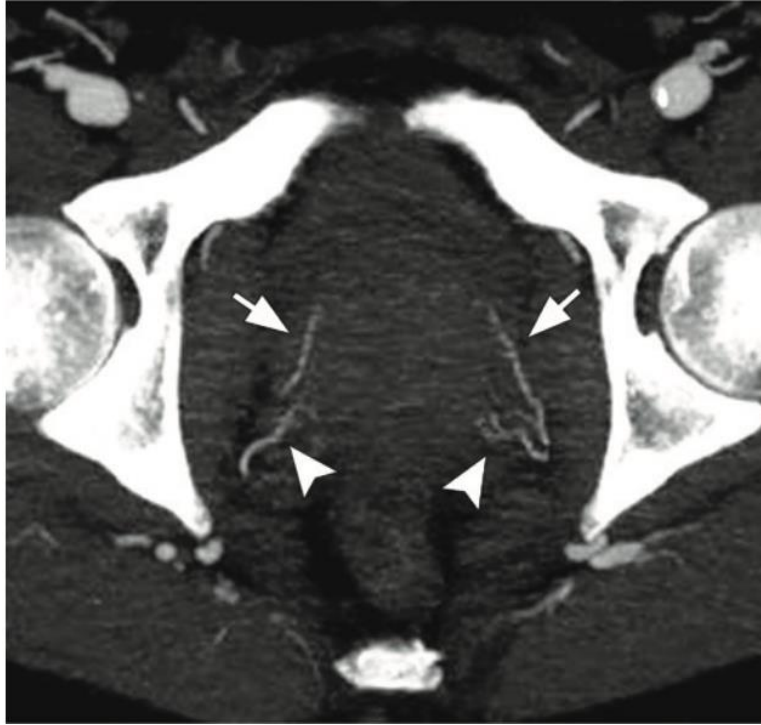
Axial CT angiogram maximum intensity projection reconstructed image showing the anterolateral/superior pedicle (arrows) and posterolateral or capsular/inferior pedicle (arrowheads) (33).
